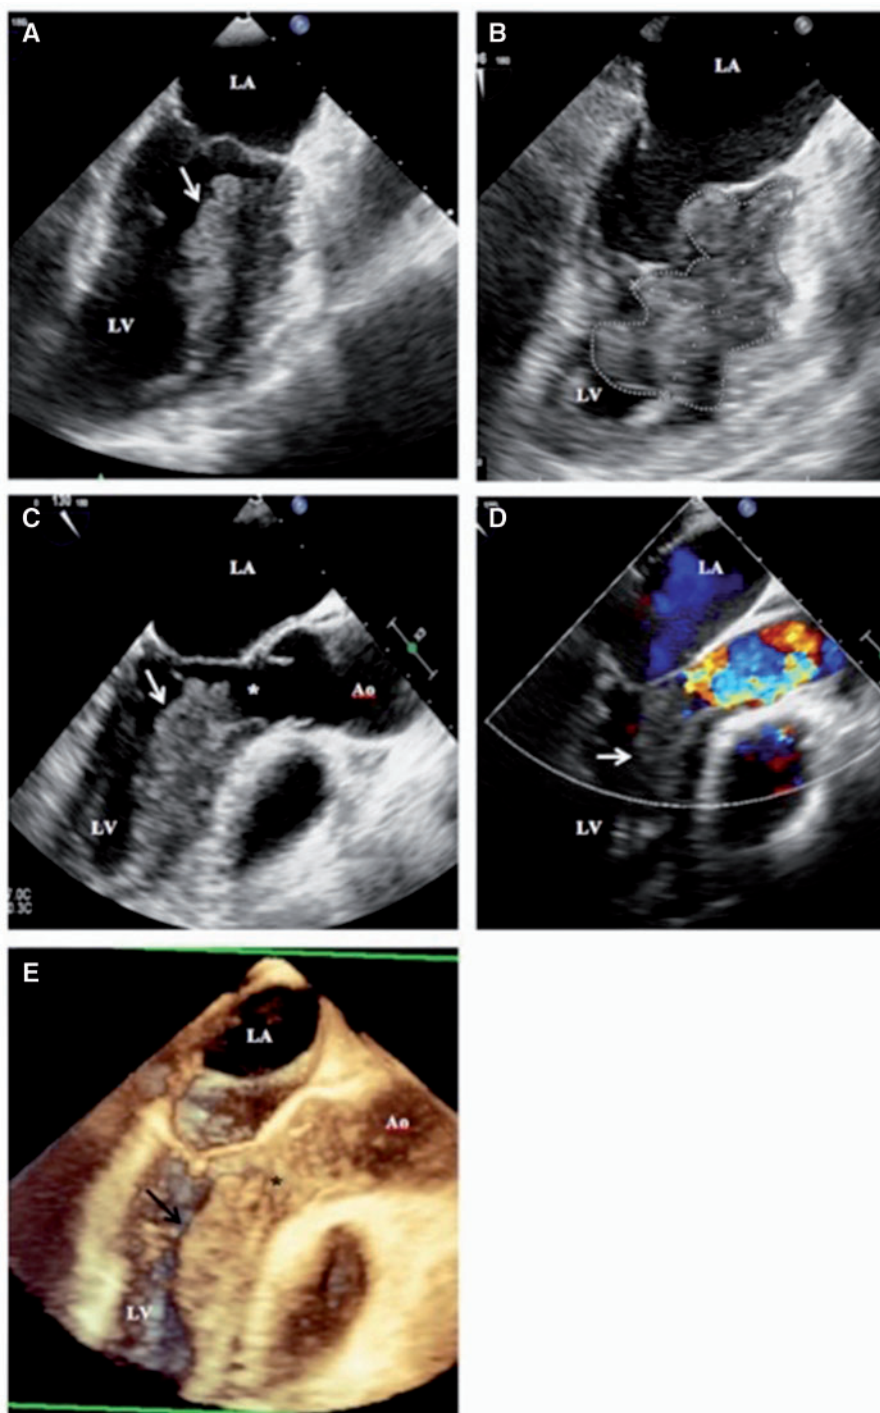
Transoesophageal echocardiogram. (A) Mid-oesophageal two-chamber view, $\sim 90^\circ$. Arrow points to mass occupying the left ventricular cavity; (B) Mid-oesophageal two-chamber view, $\sim 90^\circ$. Dotted tracing outlines the irregularly shaped mass invading the anterior wall of the myocardium. Mass was measured at 5.4×3.3 cm with calculated area of 12.2 cm²; (C) Mid-oesophageal left ventricular outflow tract view, $\sim 130^\circ$. Arrow points to mass encroaching into the left ventricular outflow tract (asterisk) during systole; (D) Colour Doppler, mid-oesophageal left ventricular outflow tract view, $\sim 130^\circ$. Turbulent flow is noted in the left ventricular outflow tract suggesting some degree of obstruction by mass (arrow); (E) 3D rendering, mid-oesophageal left ventricular outflow tract view, $\sim 130^\circ$. The mass (arrow) is shown partially obstructing the left ventricular outflow tract (asterisk) during systole. Ao, aorta; LA, left atrium; LV, left ventricle.
